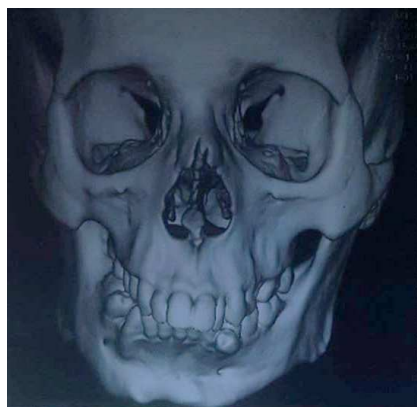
Pre Operative CT Scan 3D (Frontal)
